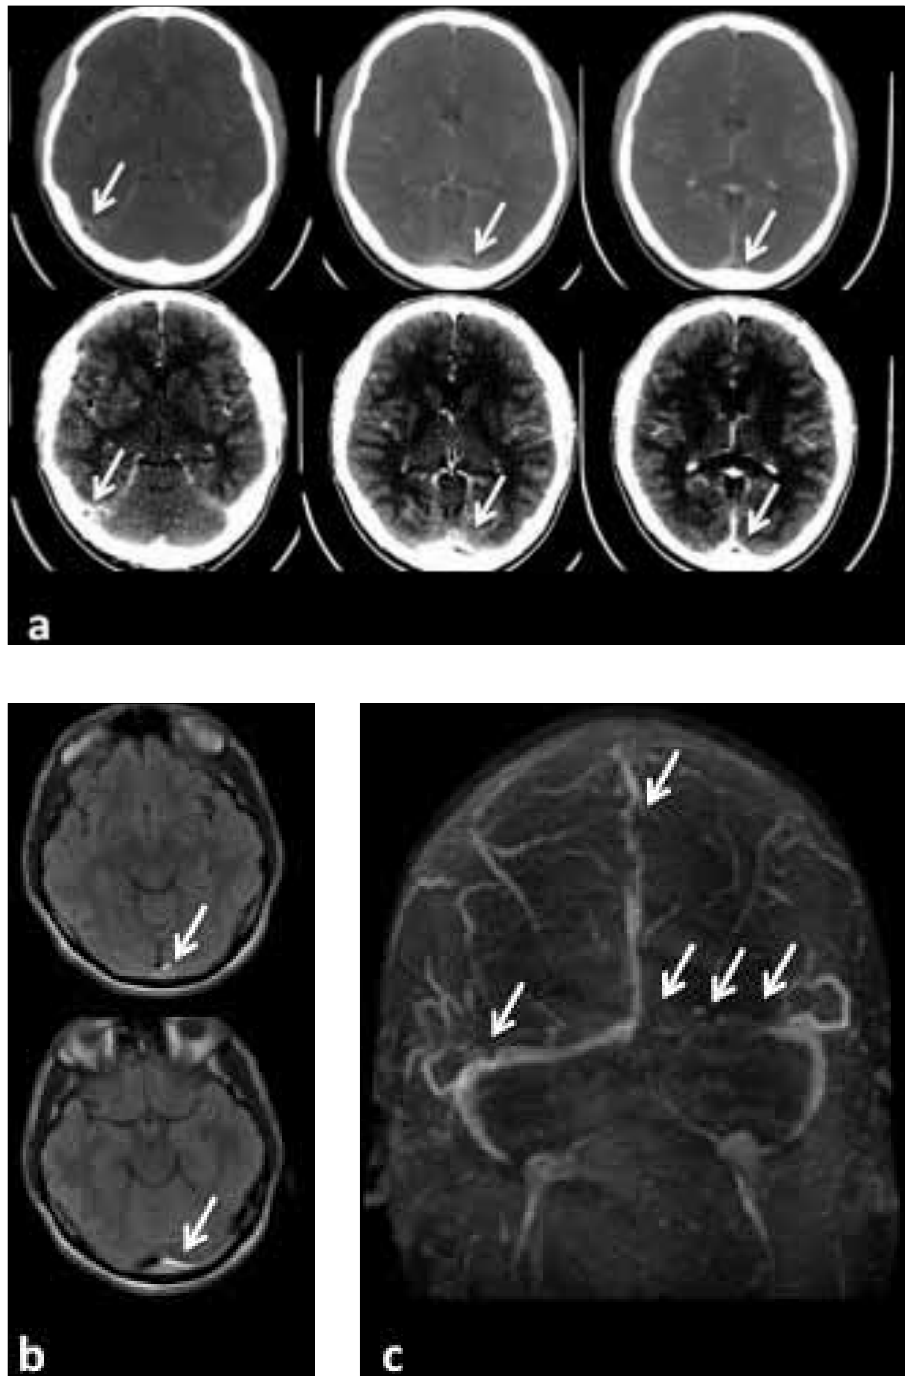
CONTRAST ENHANCED HEAD CT
